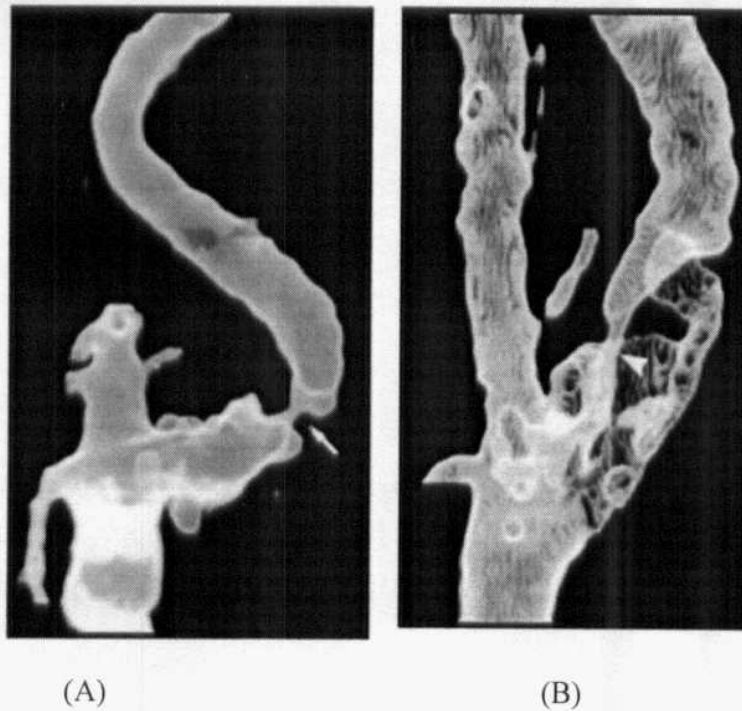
(A) Volume-rendered CT image demonstrates excellent delineation of the artery outlines. (B) Volume-rendered CT image depicts the entire portion of the stenosis (arrowhead) with accuracy despite the calcification. Thereby enables accurate measurement of the stenosis (arrow). (Quoted from Rubin et al., 1995).
